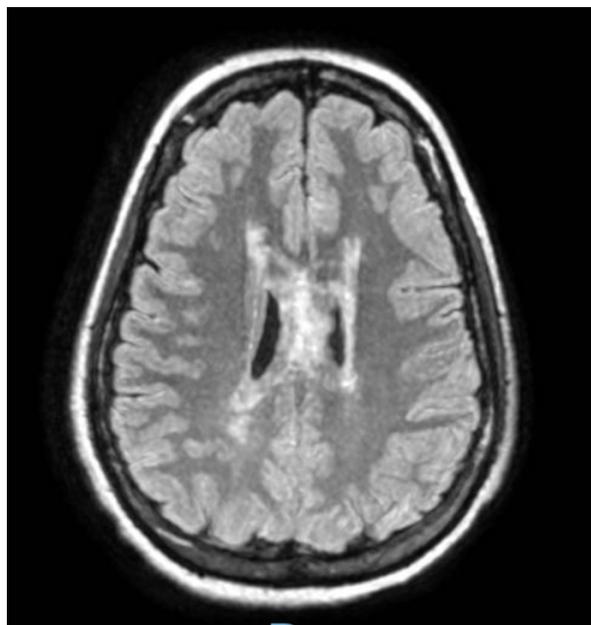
Imagem de RM de encéfalo em sequência FLAIR com corte axial com alteração de sinal periventricular e corpo caloso com lesão em “arco de Ponte”. Paciente 35 anos DENMO Anti-AQP4+.
